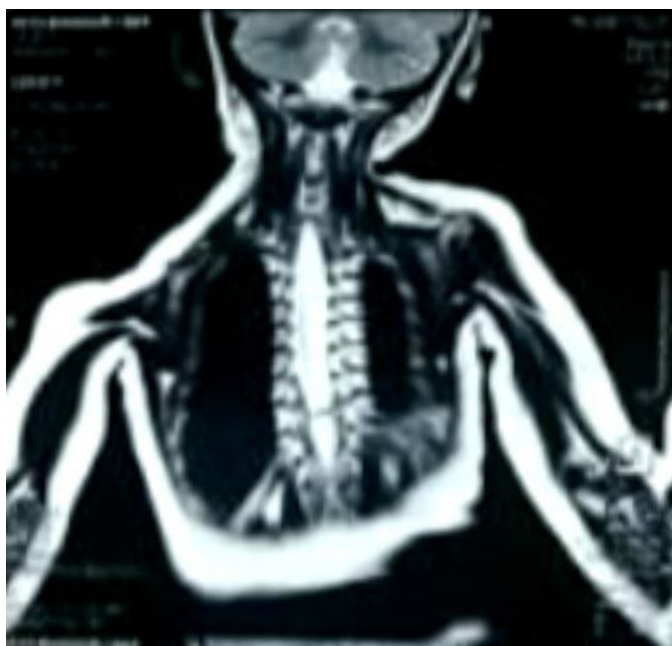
MRI whole spine, coronal section shows a large well defined fat contained predominantly extramedullary intradural lesion extending from C5 to L1 vertebral level s/o lipoma.
